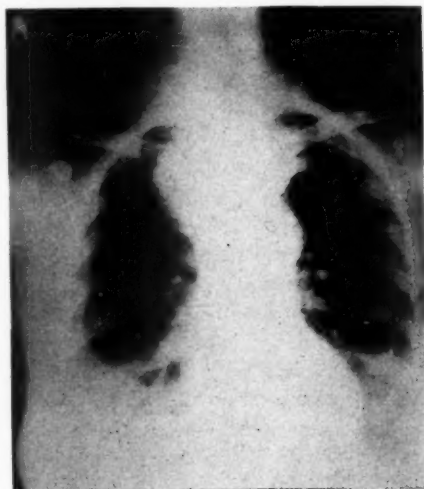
X-ray plate of intra-thoracic goiter. The arch of the aorta is displaced slightly to the left.
